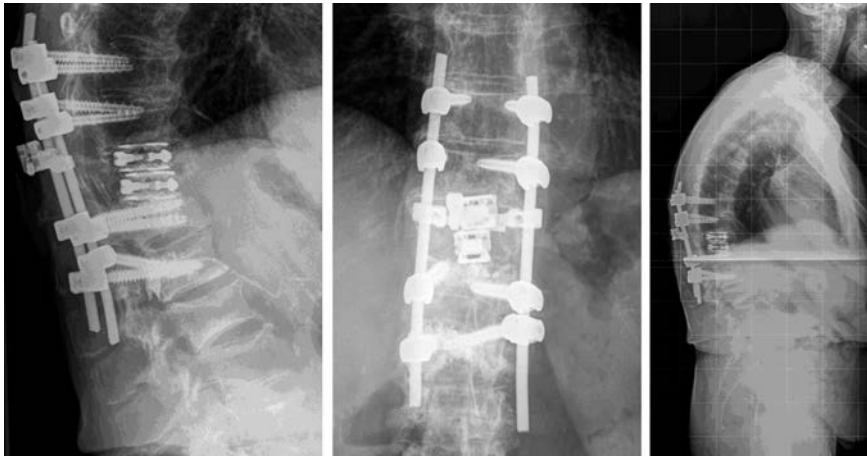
The radiographs of the spine in two planes show the result after 4 months post-operatively.
